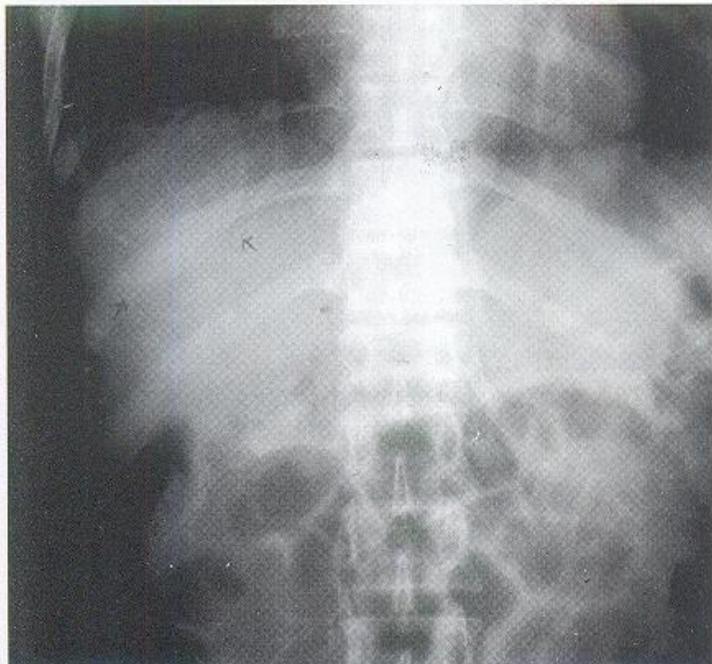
Plain X-ray abdomen showing calcification in liver. It could be calcified amoebic liver abscess/calcified hydatid cyst.
